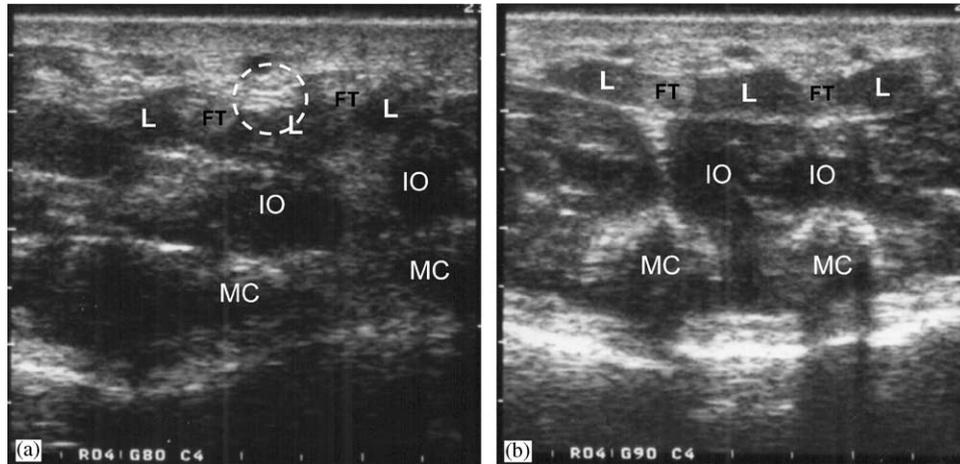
(a) Ultrasound taken 10 days after injury showing an enhancement in the third lumbrical next to the flexor tendons in the proximal part of the palm corresponding to an organized haematoma (dashed circle). (b) Ultrasound taken 4 years after injury showing normal lumbricals with almost equal diameters (L: lumbricals; FT: flexor tendons; IO: interossei; MC: metacarpal bones).
